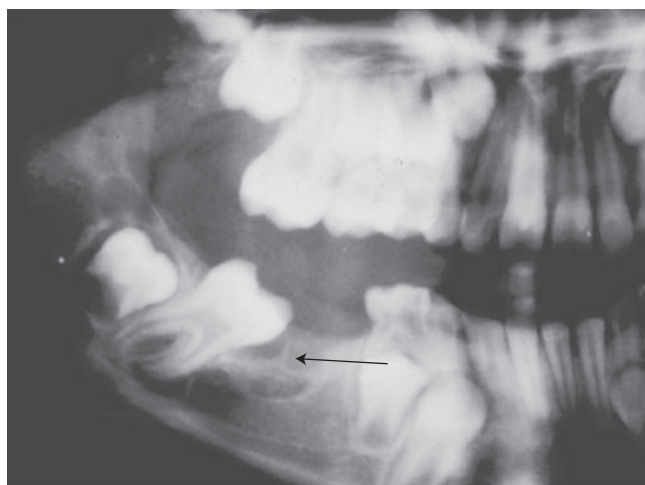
Radiograph of ameloblastic fibroma. (Courtesy of Dr. Harvey Kessler.)
